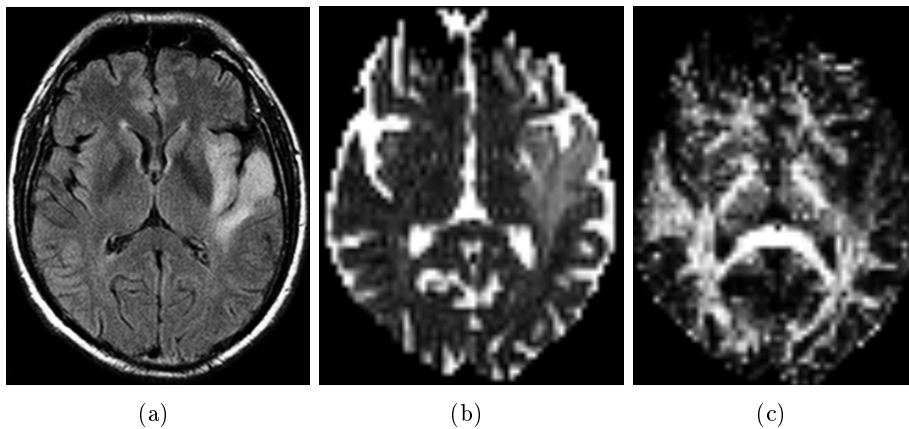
The DT-MRI images can show different effects of the tumor to the fiber structures providing us another mean to visualize the pathology. (a) FLAIR image of a grade II astrocytoma, (b) Mean Diffusivity (MD) image of the same patient derived from the DT-MRI, (c) Fractional anisotropy (FA) image of the same patient again derived from the DT-MRI. We observe that in the tumor region the MD image shows extra enhancement while the FA image shows degradation in the same region.
